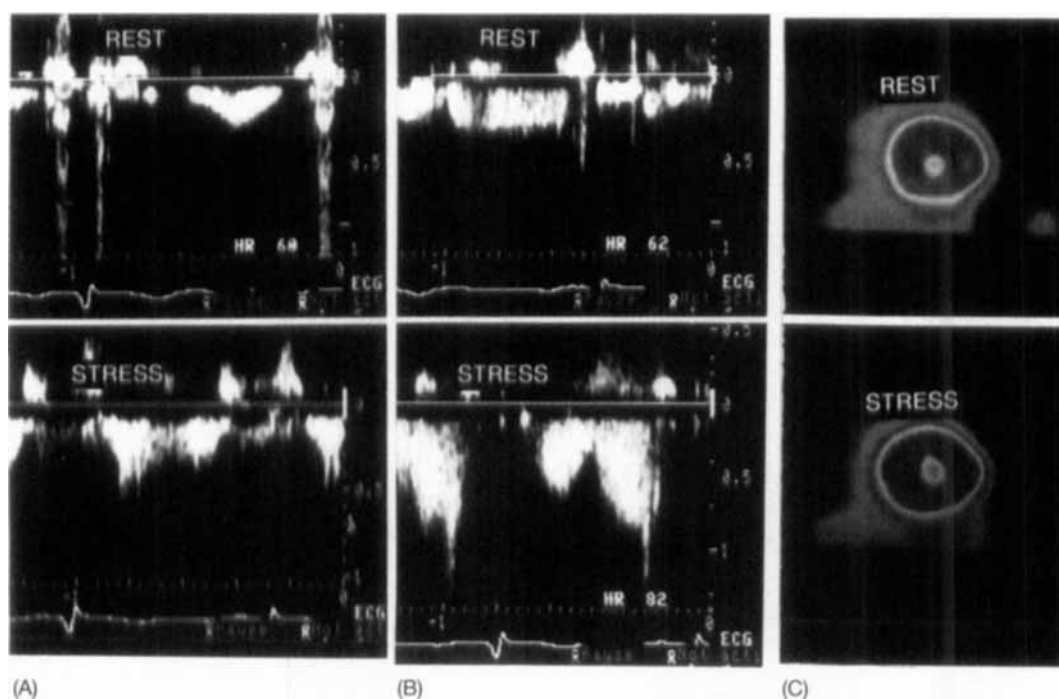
Patient with 44% area stenosis of the proximal left anterior descending (LAD) artery. (A) Transesophageal Doppler flow velocity recording in the coronary sinus at baseline and after dipyridamole resulting in a coronary flow reserve of 2.3. (B) Transesophageal Doppler flow velocity recording in the proximal LAD at baseline and after dipyridamole resulting in a coronary flow reserve of 2.4. (C) Short-axis adenosine stress/redistribution tomograms at the midventricular level demonstrating normal perfusion.
